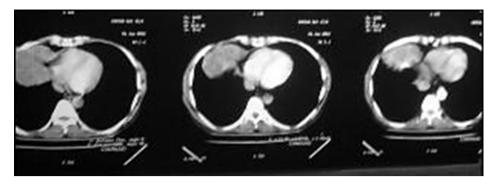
CT, mass right hemi thorax.
